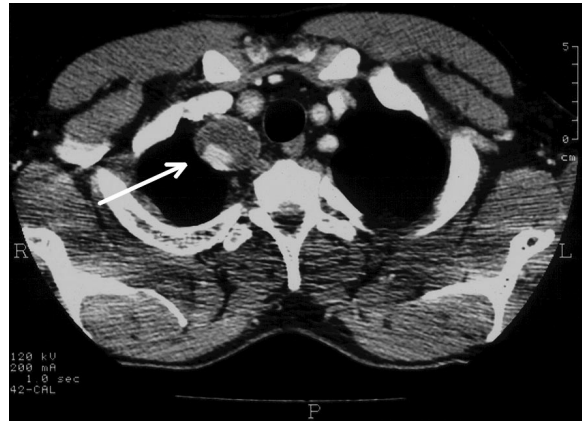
♦ Preoperative CT scan showing mural thrombus (arrow) in the innominate artery aneurysm.
